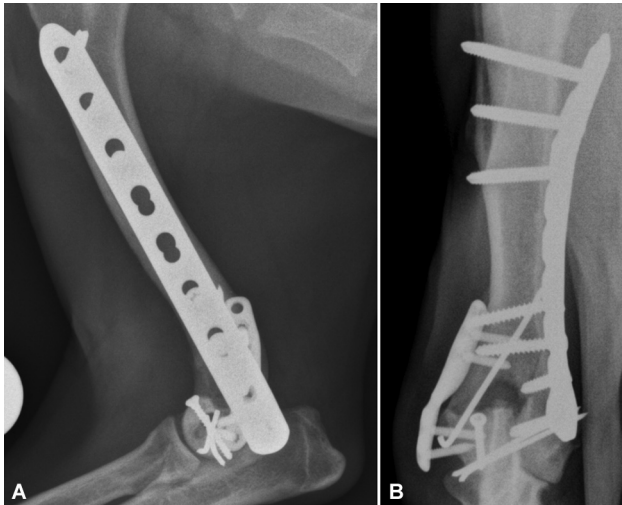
Mediolateral and craniocaudal postoperative radiographs of case 5. (A, B) show the addition of a 2.4-mm lag screw across lateral epicondylar fissure fracture and two transcondylar 1.4-mm Kirschner wires. Note that the primary transcondylar screw was removed.
